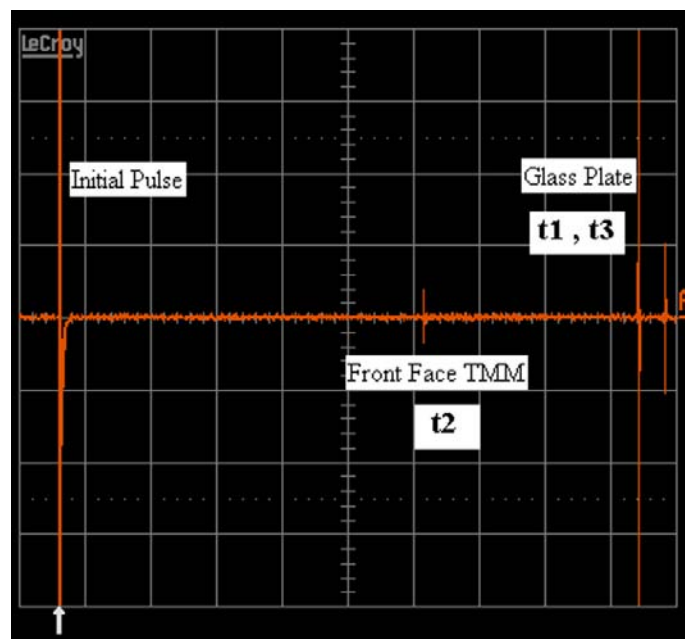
Scope screenshot showing initial pulse and its reflections. t_2 shows the reflection from surface of TMM to quantify TMM thickness. The glass plate reflection will give t_1 as reference water signal and time shifted t_3 when the TMM lies in the ultrasound path.
